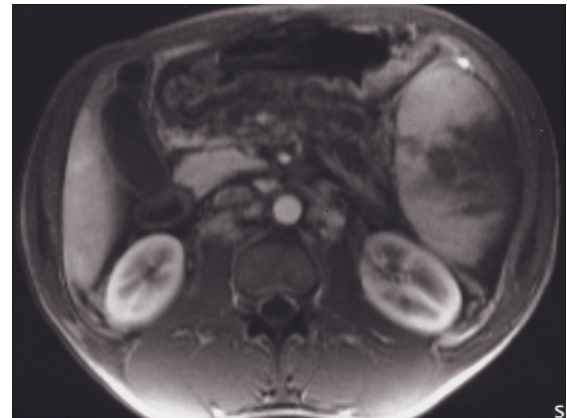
Chronic lymphocytic leukemia. The spleen is noted to be massively enlarged and contains irregularly marginated focal low-signal-intensity masses on the 45-s postgadolinium T1-weighted SGE image.
